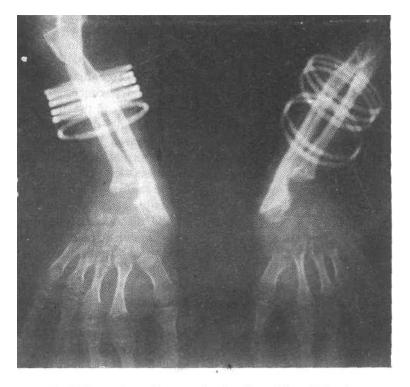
X-ray of wrist PA view showing the madelung deformity.
